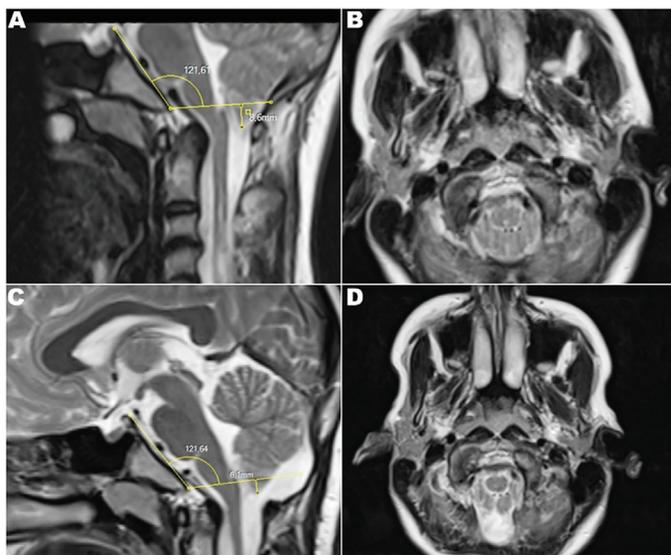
Postoperative reconstruction of the McRae line using Boogard's angle (BooA). After posterior fossa decompression, when the opisthion is no longer identifiable, a virtual McRae line can be reconstructed by projecting a horizontal line at the level of the BooA along Wackenheim's clivus canal line passing through the basion. This allows standardized measurement of tonsillar ectopia on postoperative magnetic resonance imaging
